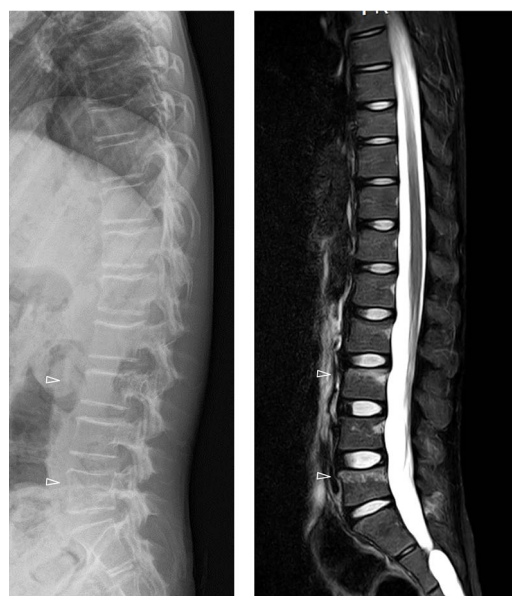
Initial fractures of the thoracolumbar spine. Radiography and short TI inversion recovery (STIR) images of magnetic resonance imaging showing compression fractures of the L3 and L5 vertebrae.
